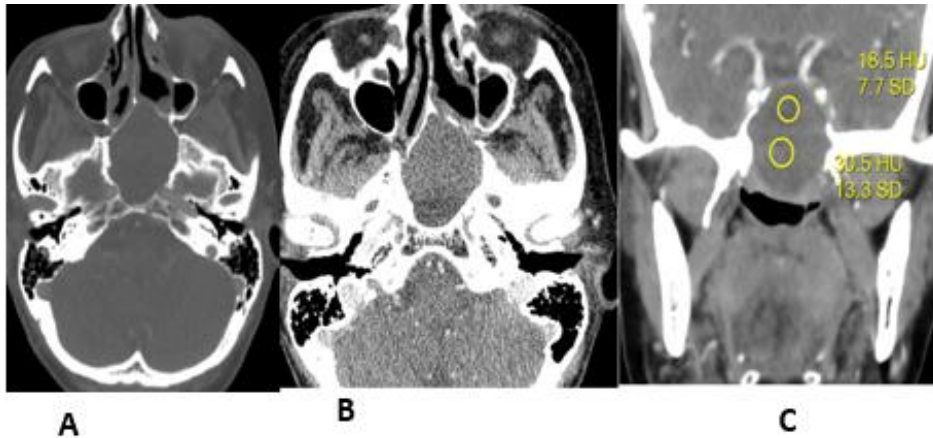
Axial bone window (A), axial soft tissue window (B) and coronal Soft tissue window (C) CT of a 56 years old female showing heterogeneous soft tissue and fluid density opacification of the sphenoid sinus with marked expansion and bone remodeling with areas of bony wall discontinuity suggesting sphenoid sinus mucocele.
